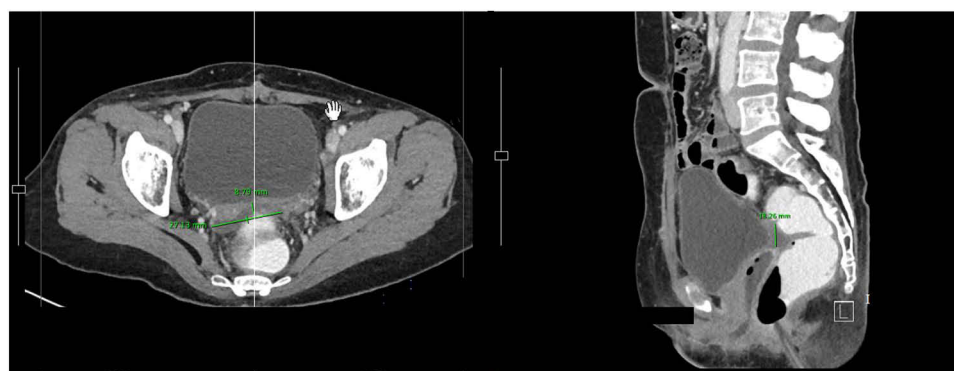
Follow-up abdomino-pelvic CT scan demonstrated improvement of the left pelvic lymphocyst after 10 days of modified dietary management, with the lesion reduced in size to 2.71 × 8.79 × 1.82 cm (green-colored lines).
